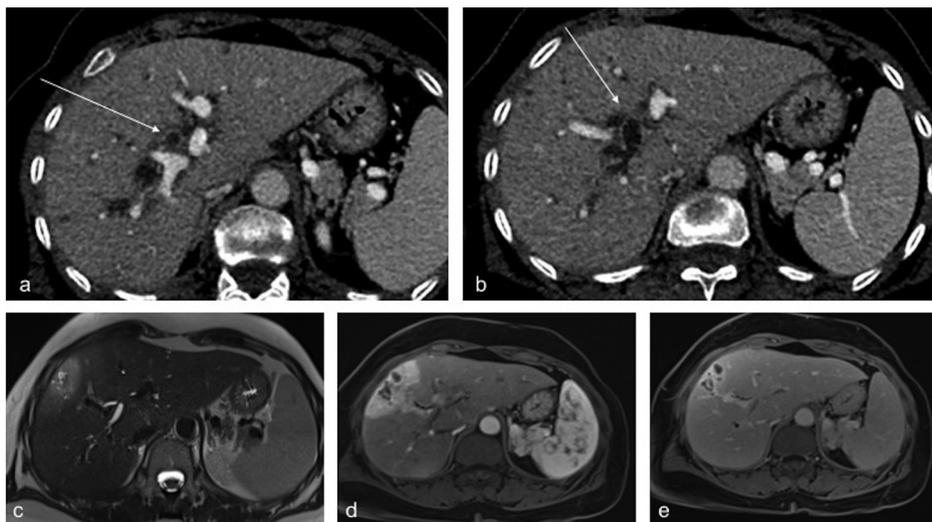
Intrahepatic complications of LPAC syndrome; a and b: CT with injection during portal phase: parietal contrast enhancement of the dilated biliary convergence and right canal (arrows) revealing cholangitis; c: bili-MRI: dilatation of the small peripheral bile ducts, with (on contact) a hepatic zone on T2 hypersignal, displaying parenchymatous edema; d: MRI, T1 sequence with gadolinium injection (arterial phase): these lesions are related with parenchymatous perfusion disorders and abscesses being formed; e: MRI, T1 sequence with gadolinium injection (portal phase): dilated peripheral bile ducts and pronounced enhancement of the abscess walls. A 63-year-old patient cholecystectomized at the age of 22 years and having repeatedly reported choledochal and right biliary tract stones, responsible for recurrent angiocholitis and intrahepatic abscess formation. Treatment with ursodeoxycholic acid was partially effective, leading to hepatectomy to treat infectious complications.
